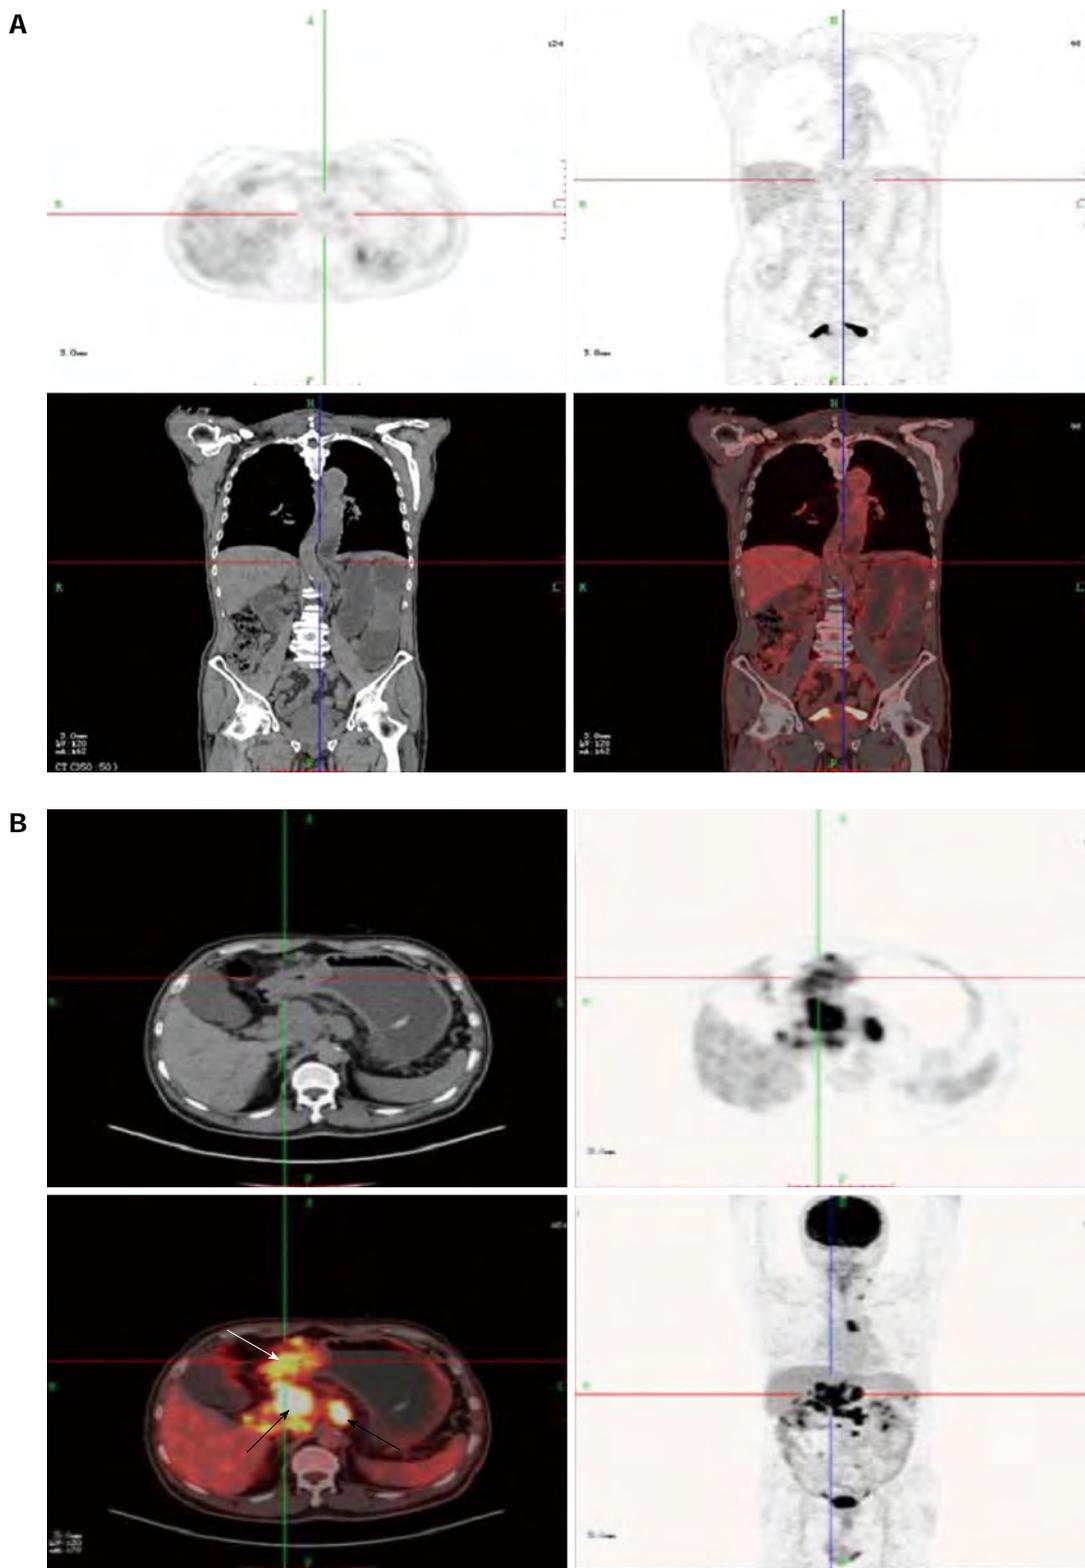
Patients who had had gastric cancer resection underwent positron emission tomography/computed tomography because of small-bowel obstruction. A: A 68-year-old man who had had gastric cancer resection 2 years previously underwent positron emission tomography (PET)/computed tomography because of small-bowel obstruction. Whole body PET projection image and axial PET image showed no focal hypermetabolic activity; B: A 38-year-old female who had had gastric cancer resection 1 year previously underwent positron emission tomography/computed tomography because of small-bowel obstruction. Whole body PET projection image and axial PET image showed the remnant stomach (white arrow) and lymph-node (black arrow) focal hypermetabolic activity.
